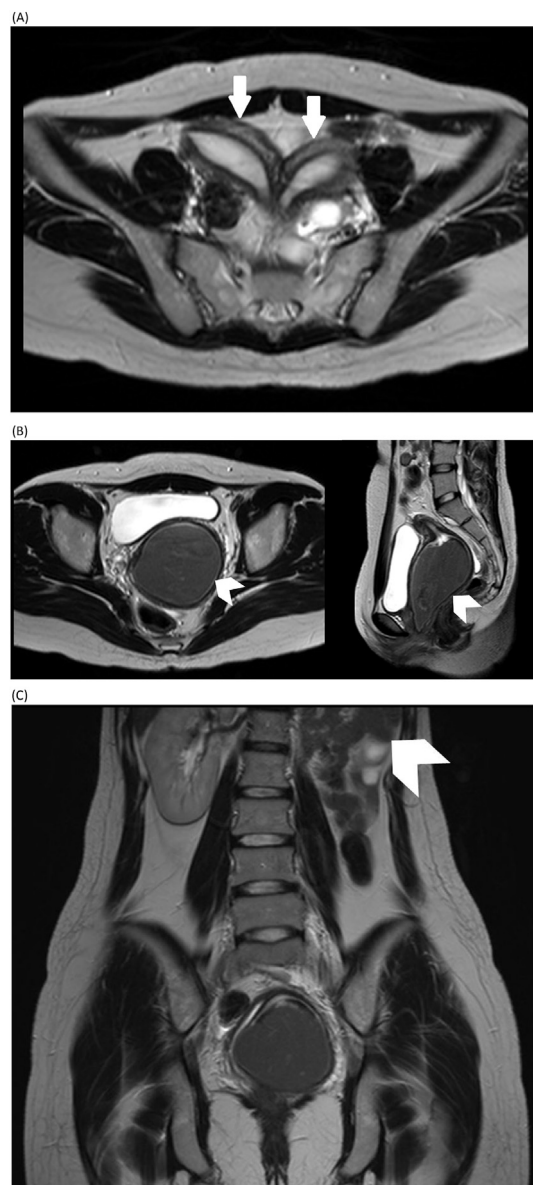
(A). Axial T2-weighted magnetic resonance (MR) image demonstrating two uterine cavities with a normal endometrium (arrow). (B). Axial and sagittal T2-weighted MR images revealing a dilated hemivagina, with suspected collection of pooled blood according to the image signal presentation (arrowhead). (C). Absence of the left kidney (arrowhead).
